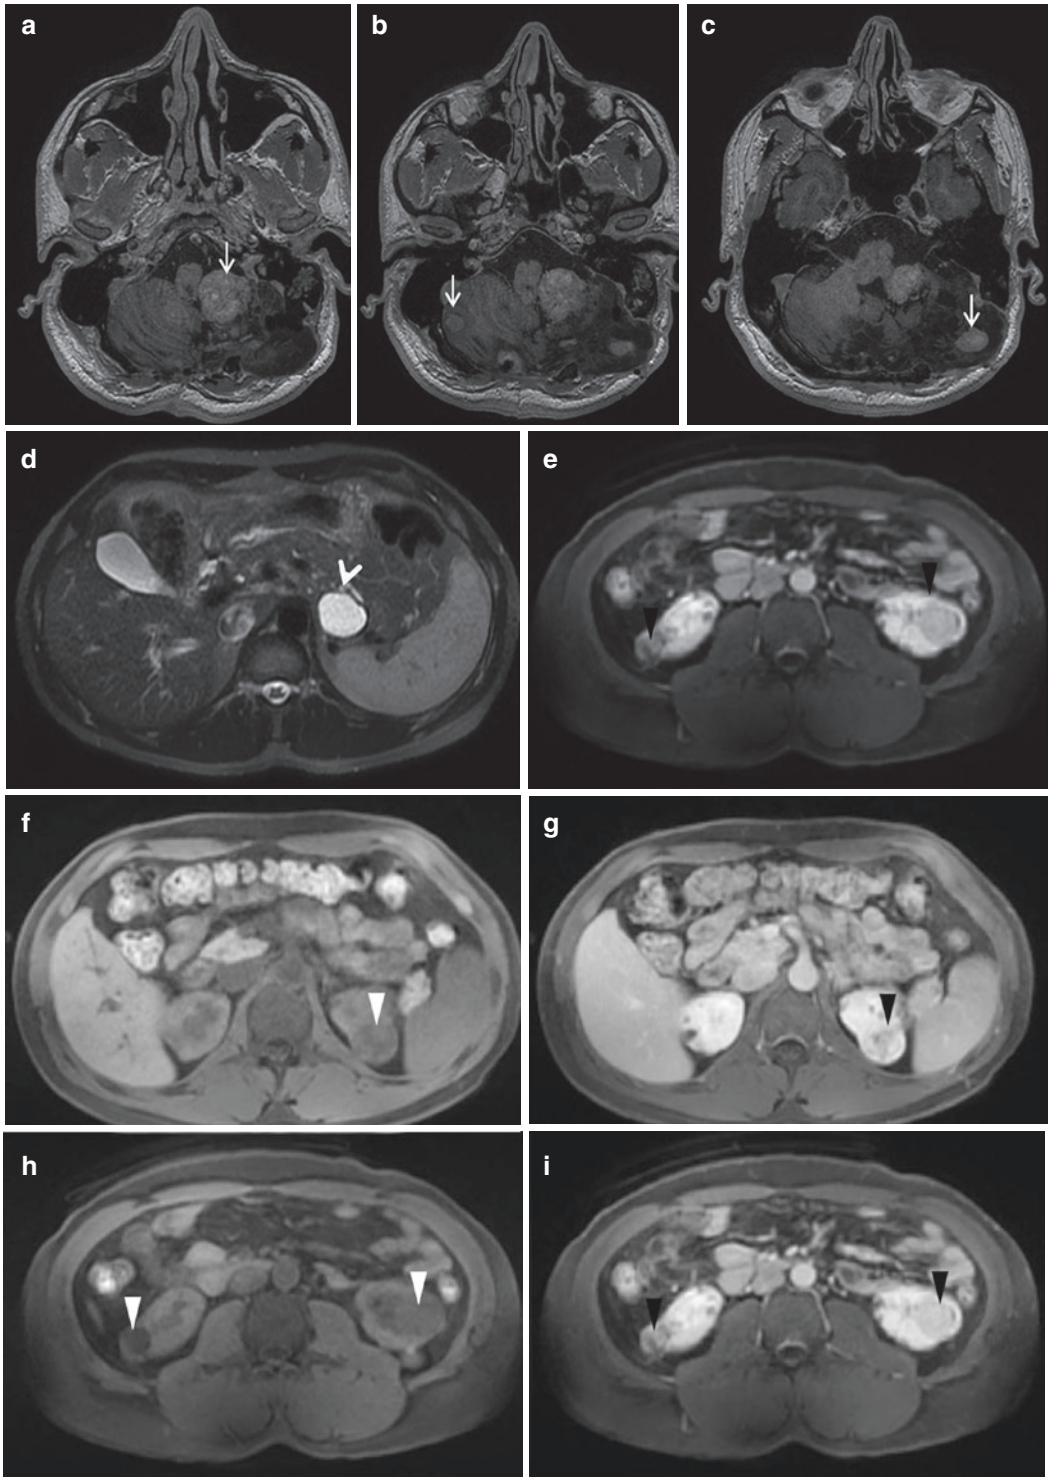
Thirty-eight years old man with von Hippel-Lindau syndrome. (a–c) On fat-saturated contrast-enhanced T1W transverse MR images, bilateral enhancing cerebellar hemangioblastomas are seen (arrows). There is also a large parenchymal defect in the left cerebellar hemisphere due to previous surgical resection. (d–e)
